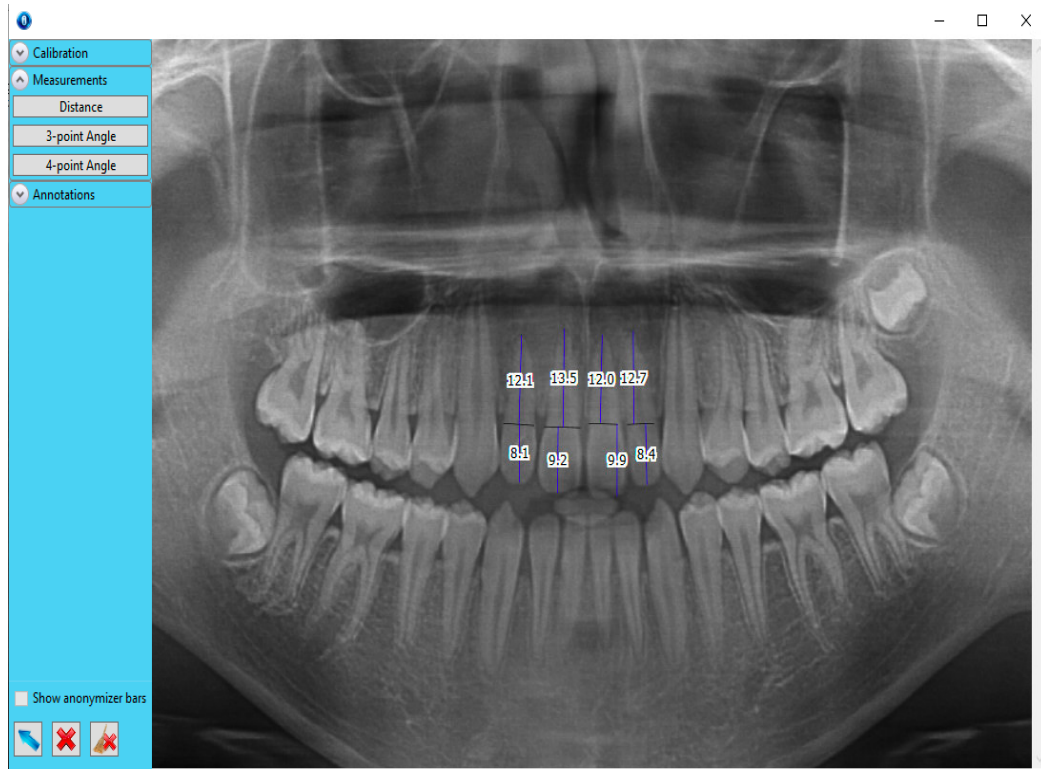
Initial panoramic radiograph measurements
